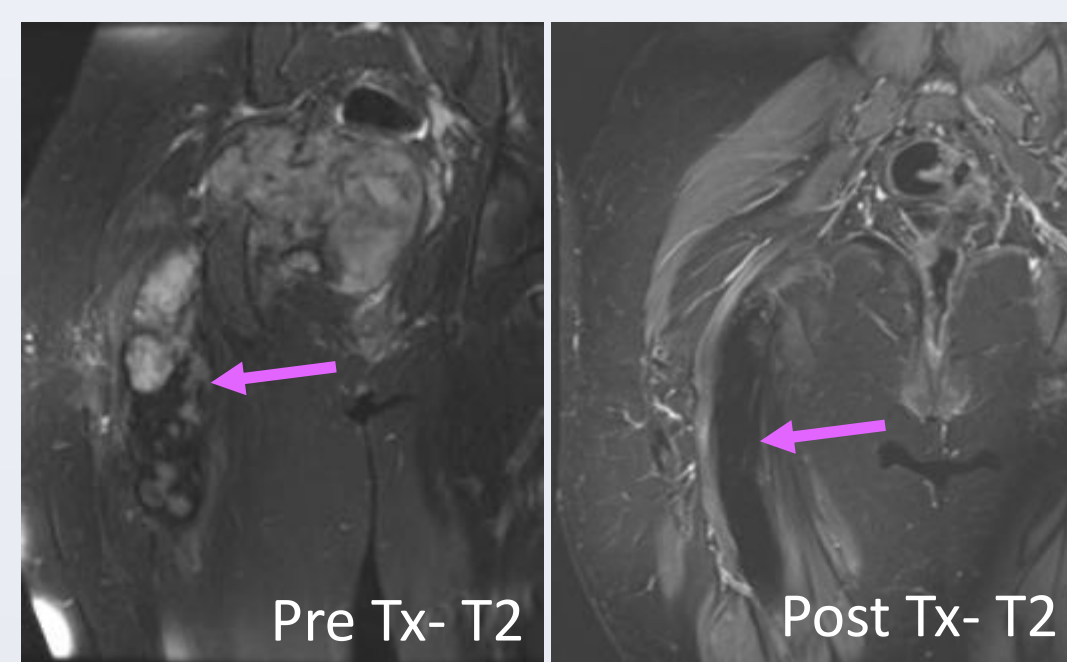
T2-fat-saturated coronal MR images of DF pre- and post- treatment
